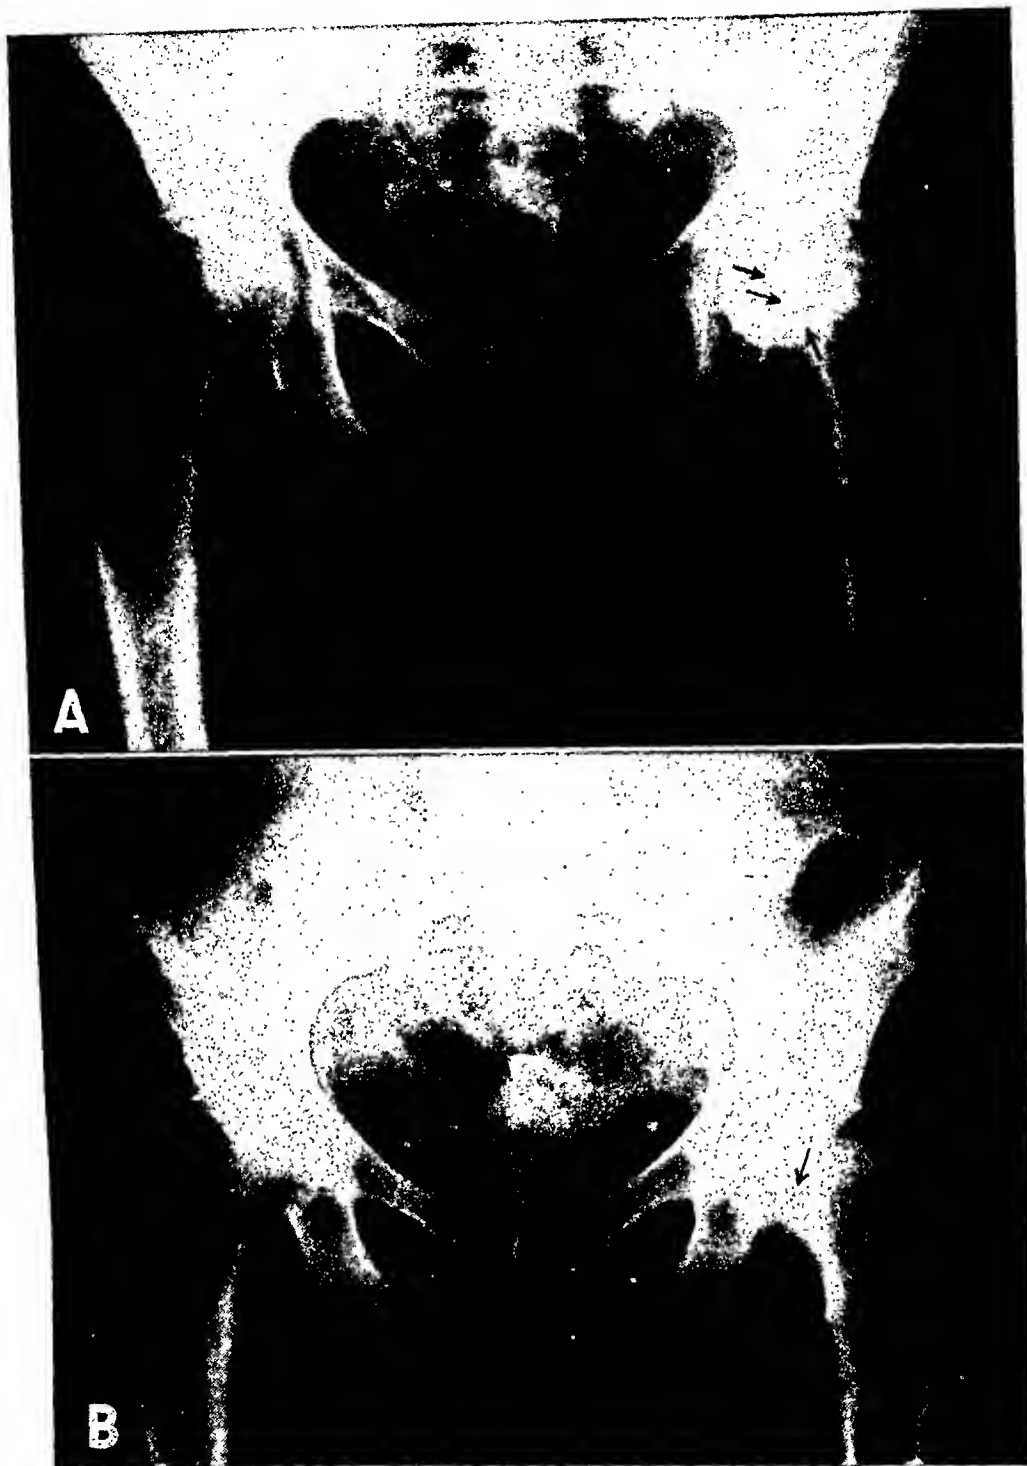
A. Feb. 20, 1936. There are several zones of increased density visible at this time. The roentgen appearance has changed considerably in six weeks. B. Feb. 15, 1938. The radiation fracture of the left hip has healed, leaving only a faint zone of increased density.
